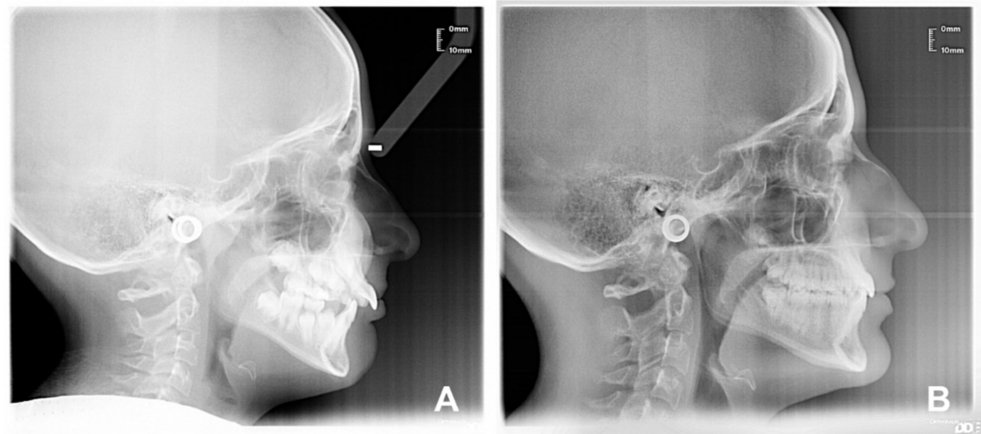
(A,B)—Patient (D.L.) latero-lateral teleradiography X-ray: before treatment T0 (A) and after treatment T1 (B).
